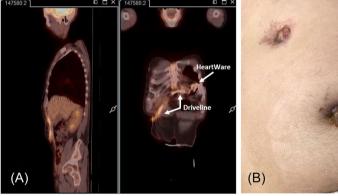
(A) Preoperative PET/CT. (B) Purulent exit site and driveline externalization fistula (admission in our center).
